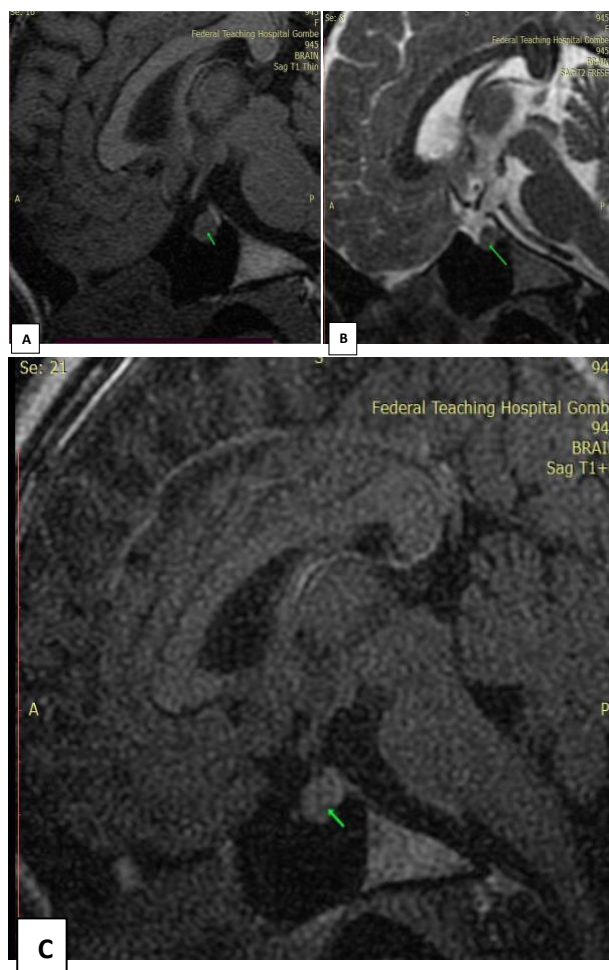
T1W(A), T2W(B) and T1W Post contrast (C) MRI mid sagittal sections showing a micro nodule noted within the pituitary gland (white arrow) It is hypointense on T1W images and isointense on T2W images and show mild enhancement post contrast with associated inferior bulge.
